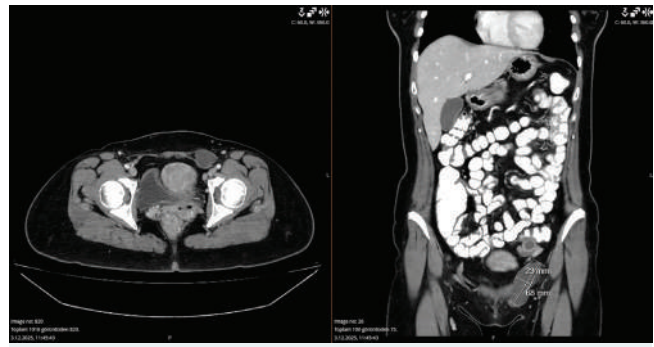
Preoperative computed tomography image of nuck canal cyst.
